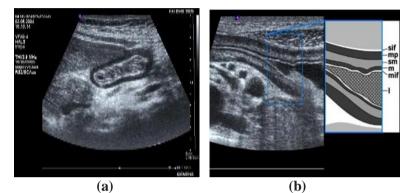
Ultrasonography of the antrum, in cross-section (a) and zoomed longitudinal section (b). (sif: serosal interface; mp: muscularis propria; sm: submucosa; m: mucosa; mif: mucosal interface; l: lumen) [17].
